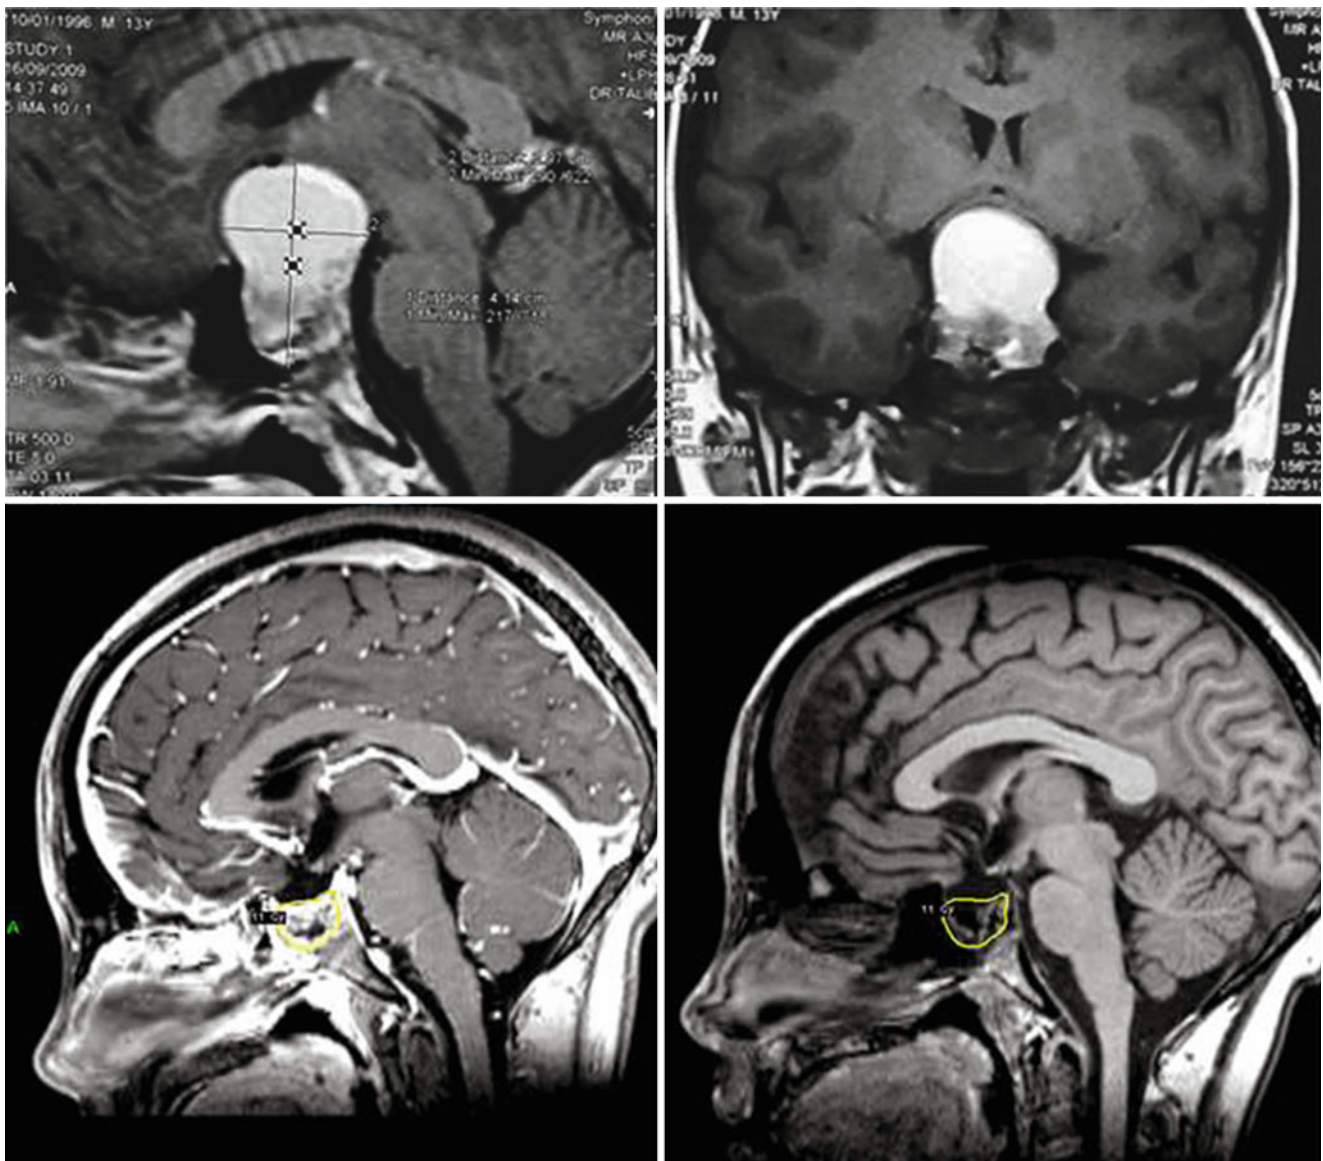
A 4-year-old boy presented with optochiasmatic syndrome. He had significantly decreased visual acuity on the right eye, whereas the left eye was blind. MRI showed a giant suprasellar craniopharyngioma (*upper row*). The patient underwent subtotal tumor removal via the left frontolateral approach. His postoperative course was favorable. Control
